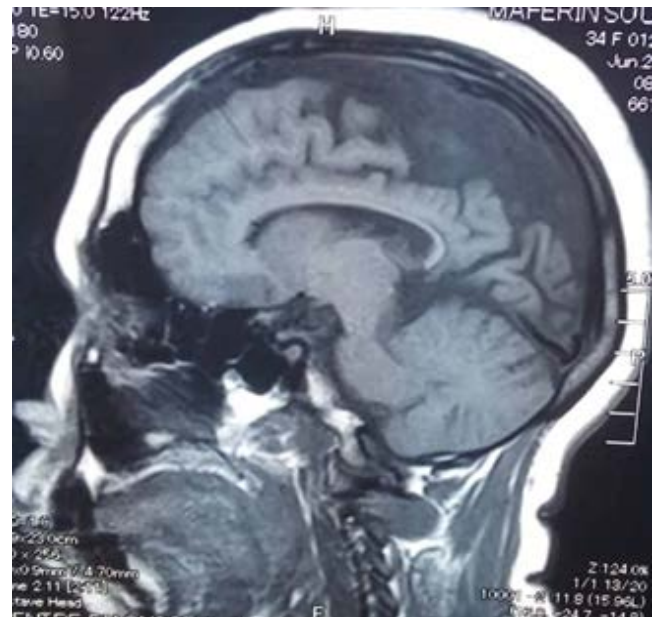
Brain MRI: sagittal section in T1Left hemi-cerebral atrophy with cortical calcifications and compensatory hypertrophy of the diploe in compatible frontal at the Sturge Weber's disease.
